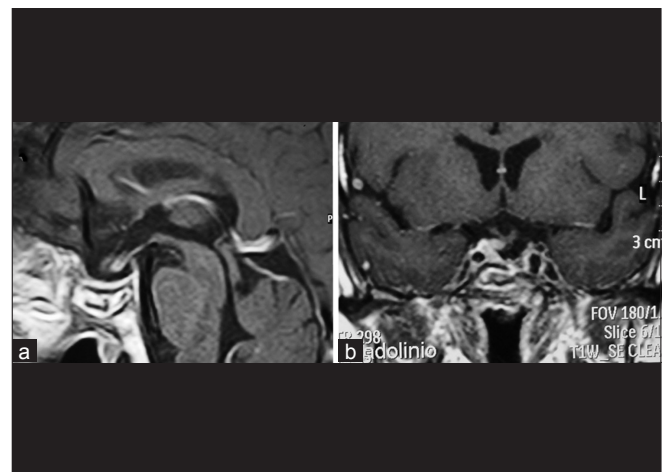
(a, b) Sagittal and coronal contrast-enhanced T1-weighted postoperative MRI showing complete resection of the tumor
